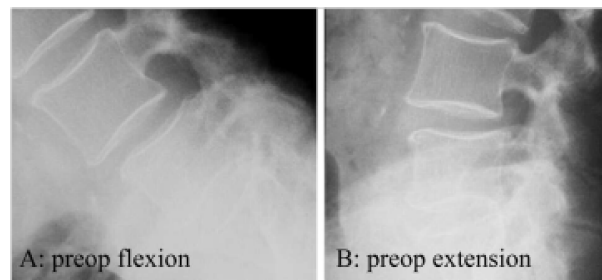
Postoperative Dynamic X-ray of previous operated site.
